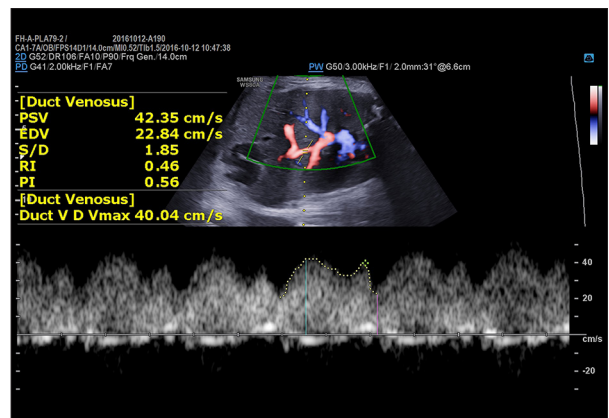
Ultrasound Doppler spectrum of fetal DV in the placenta previa group.
